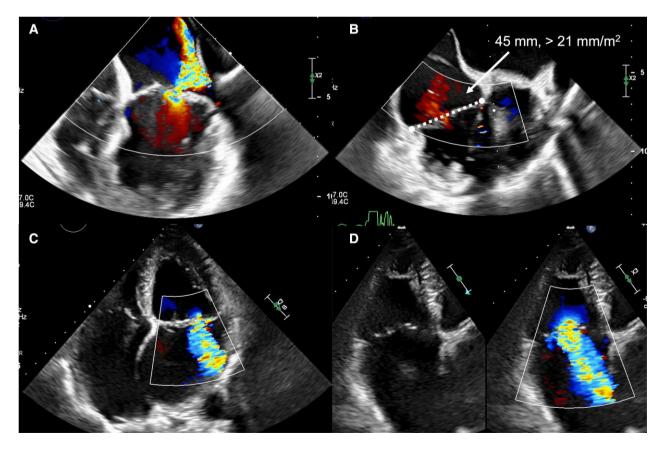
Echocardiographic images of combined mitral and tricuspid valve disease. Severe degenerative mitral regurgitation (*A*) and coexisting nonsignificant functional tricuspid regurgitation (*B*), but with annular dilation (septal-lateral diameter 45 mm, $> 21 \text{ mm/m}^2$) as shown by transesophageal echocardiography. Atrial functional mitral (*C*) and tricuspid (*D*) regurgitation as shown by transthoracic echocardiography.
